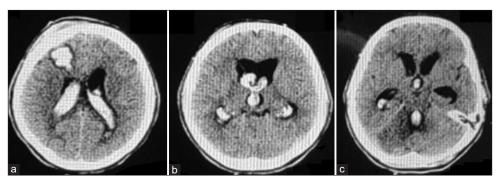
(a-c) Emergency brain computed tomography scan after external ventricular drainage (EVD) removal showing acute hemorrhage along the EVD path and within the lateral and third ventricles. Furthermore, signs of obstructive hydrocephalus.
